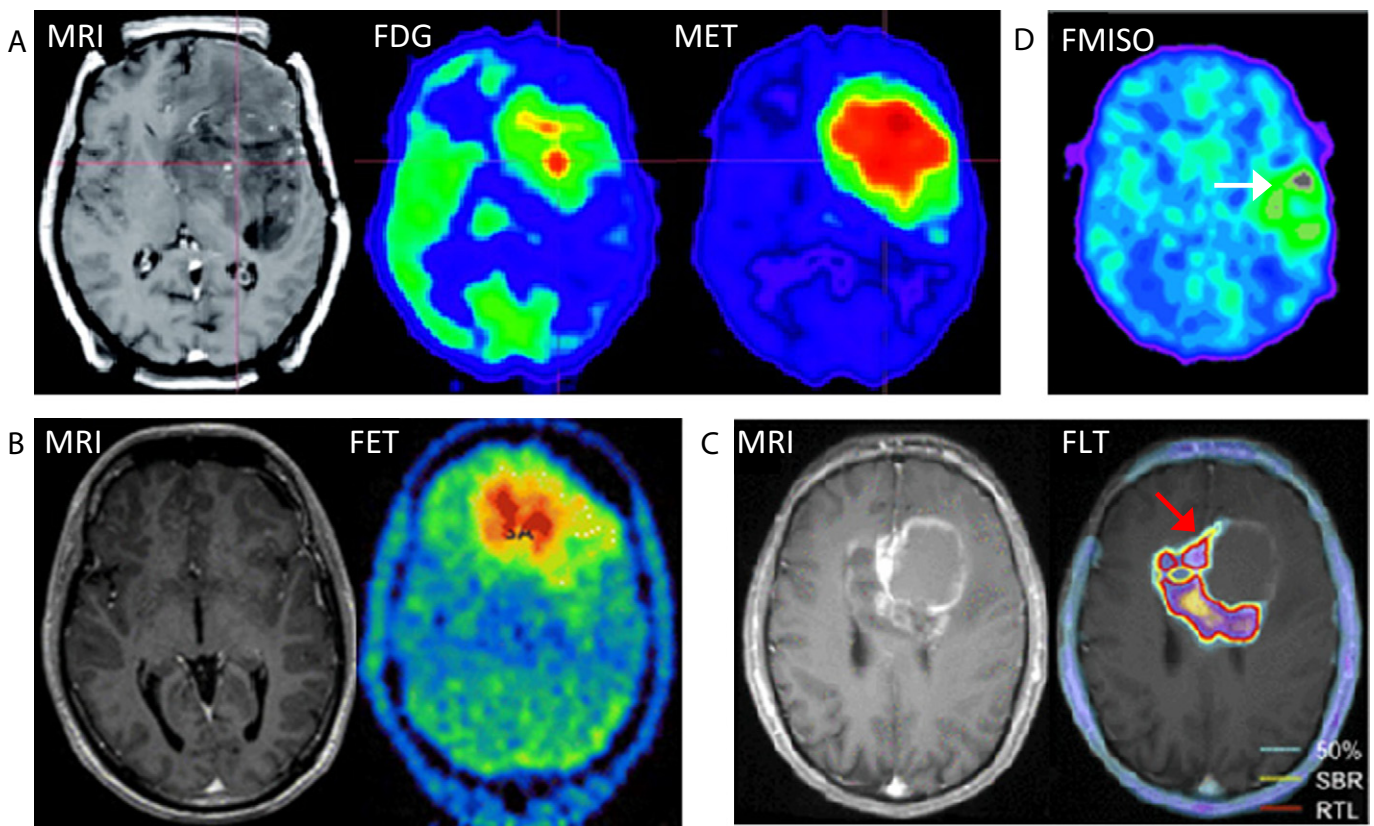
Molecular imaging of brain tumors with PET. Typical PET tracers used for molecular imaging of gliomas in the clinic (highest PET activity shown in red): (A) Metabolic imaging of an infiltrating anaplastic astrocytoma patient. Uptake of ^{18}F -FDG is higher in the tumor than in the surrounding gray matter. Uptake of ^{11}C -MET is also higher in the tumor and extends beyond the area of high FDG uptake. (B) ^{18}F FET-PET of a second glioma patient treated with antiangiogenic therapy, showing high tracer uptake despite the absence of contrast enhancement in MRI. (C) ^{18}F -FLT overlaid on MRI for a third GBM patient, showing high uptake values indicative of high tumor cell proliferation in the tumor compartment infiltrating through the corpus callosum (red arrow). 50%, SBR and RTL lines denote different segmentation methods (see ref [208] for details) (D) ^{18}F -FMISO scan of a fourth patient with a GBM in the left temporal lobe, showing the accumulation of the tracer in hypoxic regions of the tumor (white arrow). Information in panels A, B, C, D reproduced and adapted with authorization from [208,237–239], © by the Society of Nuclear Medicine And Molecular Imaging, Inc. ^{18}F -FDG: ^{18}F -fluorodeoxyglucose, ^{11}C -MET: ^{11}C -methionine, ^{18}F ET: ^{18}F -fluor-ethyl-tyrosine, ^{18}F -FLT: ^{18}F -fluorothymidine, ^{18}F -FMISO: ^{18}F -fluoromisonidazole.
